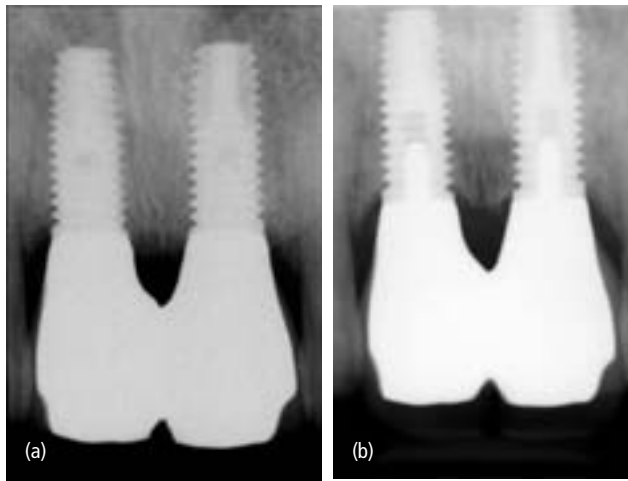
(a) Periapical radiograph taken immediately after completion of prosthetics. (b) Periapical radiograph taken 3.5 years later, at time of referral.
